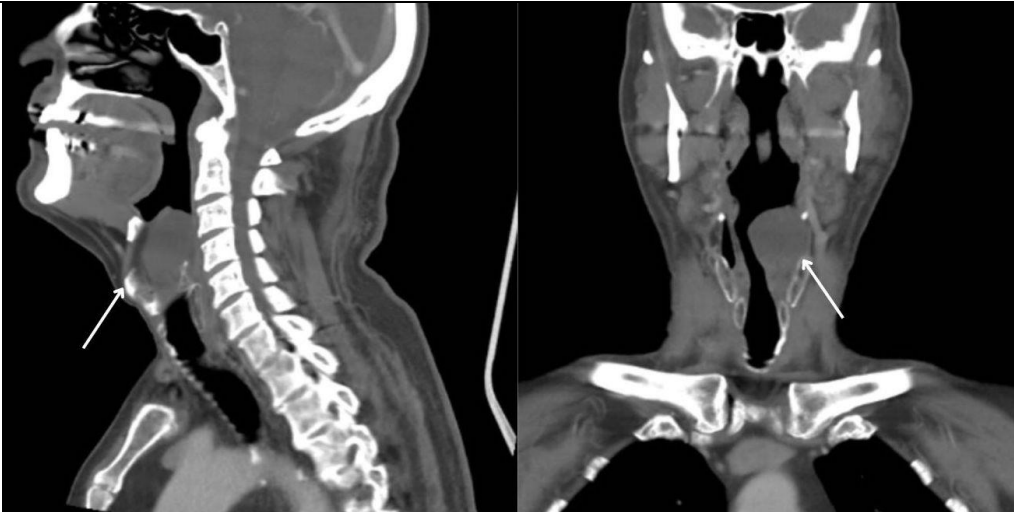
Computed tomography of the neck, showing a hypodense formation in the fat of the left paraglottic space measuring 2.7 x 2.7 cm, causing local bulging with reduction of the airway column in the glottic and supraglottic larynx.
